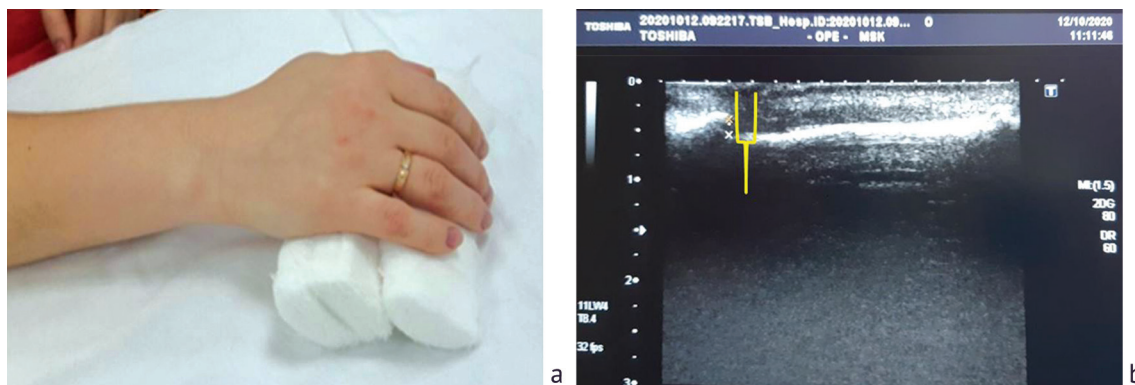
Ultrasound examination of the injured finger of the right hand of patient L.: a physiological position of the hand; b maximum convergence of the damaged ends of the tendon by 1.4 mm
